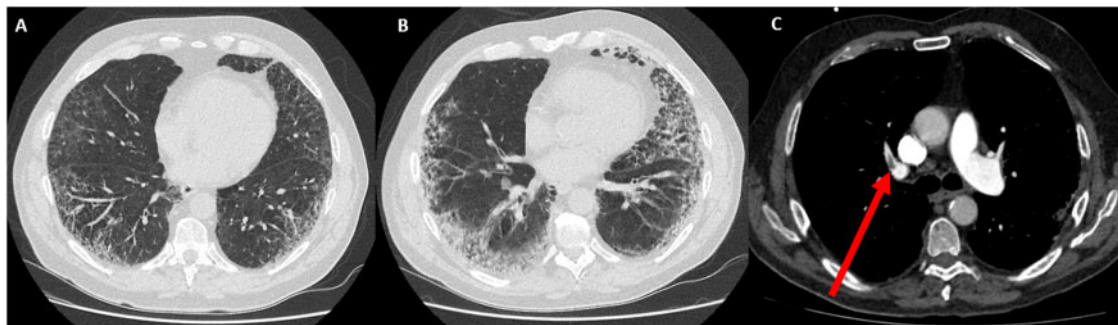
Serial chest computed tomography scans of Patient 1. (A) Low dose computed tomography scan on the first hospitalization showing peripheral ground-glass opacifications with underlying centrilobular emphysema lesions. (B) High resolution computed tomography scan (lung window) on readmission showing an increase in infectious lesions of ground-glass opacifications with an extension of 30% of lung parenchyma with predominant consolidation in the lower lobes. (C) Computed tomography angiography showing filling defect (arrow) in the right pulmonary artery and its right superior lobe divisions.
